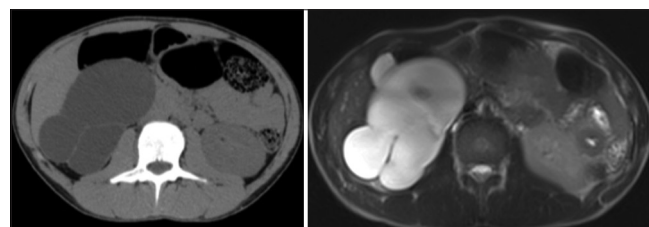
Axial non-contrast computed tomography image (left) shows Grade-4 hydronephrosis with pelviureteric junction obstruction on right side with similar findings on axial T2W magnetic resonance image (right)
